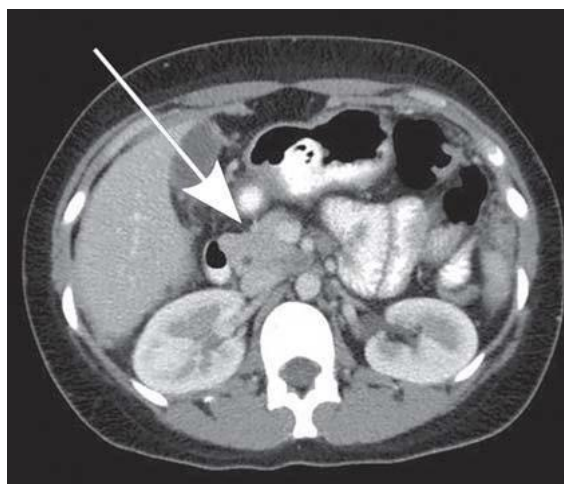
Extrapulmonary manifestation of tuberculosis (TB) with abscess formulation around the abdominal aorta and upper field of the right lung (chest radiograph, p.a. view)
